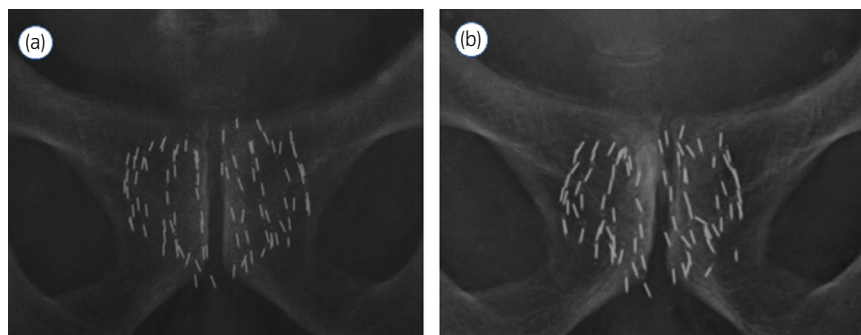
(a) X-ray after brachytherapy showed no evidence of seed migration to the urethra. (b) No obvious seed migration was detected on X-ray images before TUR of the mucosa with erythema.
